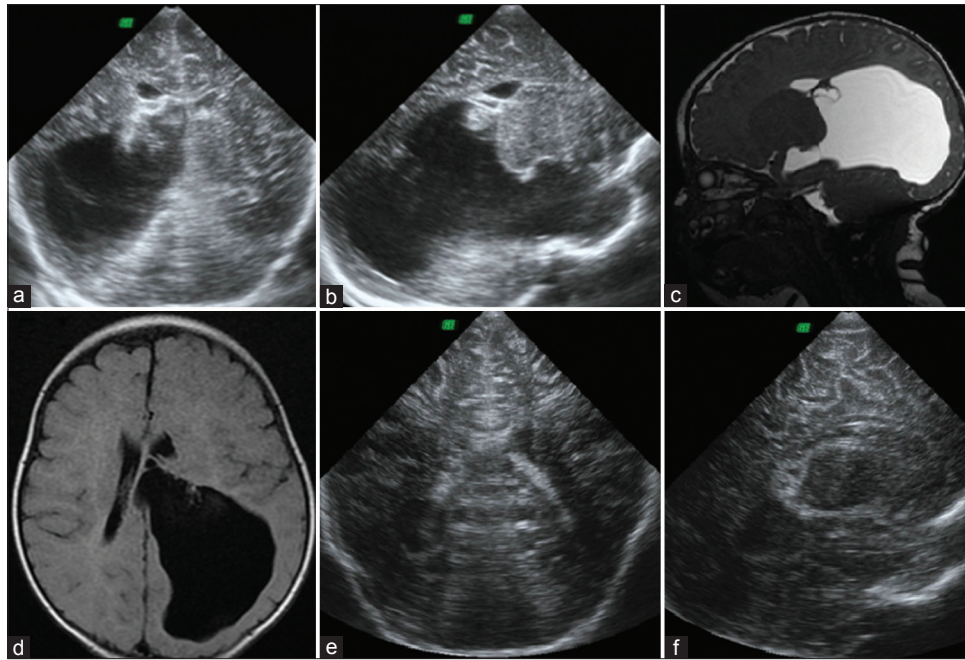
Trapped temporal horn with marked dilatation of the left ventricle detected in case 2 by brain sonography in the coronal view (a) and left parasagittal view (b). The same findings were noted in brain magnetic resonance imaging sagittal view image (T2 image) (c) and axial view image (T2 fluid-attenuated inversion recovery image) (d). Follow-up brain sonography after neuroendoscopic cystoventriculostomy showed significantly decreased size of the left lateral ventricle (e and f)
